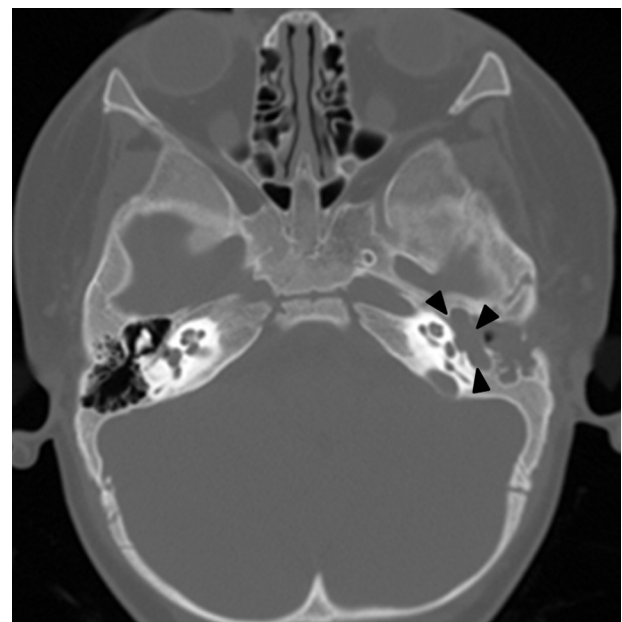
CT image on the horizontal plane. The left mastoid was filled with a soft mass. The left facial nerve was enlarged at the horizontal portion, with destruction of the surrounding bone (black arrowheads).
